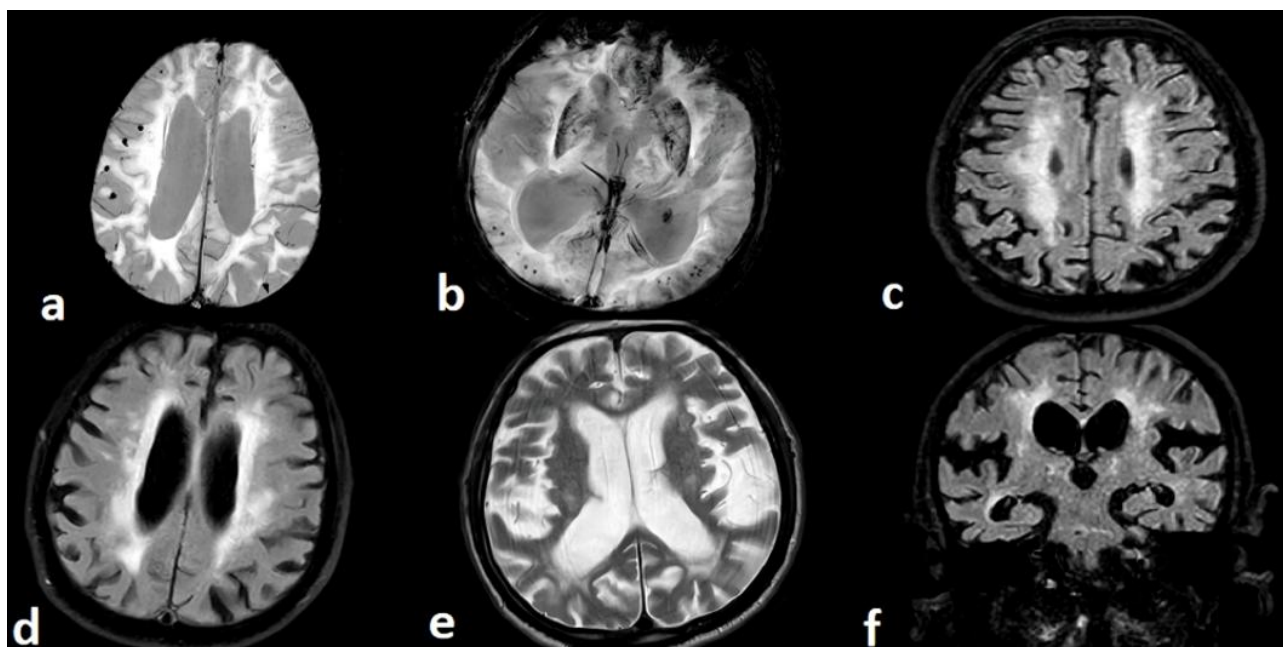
Cranial magnetic resonance imaging of the patient: Microbleeding on the different area of the cerebral cortex on SWI sequential imaging (a & b), periventricular hyperintensities extending to the subcortical white matter on different level of axial plan on T2-weighted FLAIR imaging (c & d), lateral ventricle enlargement on the axial plan (e), & callosal angle $< 90^\circ$ on the coronal plan (f) (Department of Radiology, Balikesir University Hospital [patient data anonymized])
